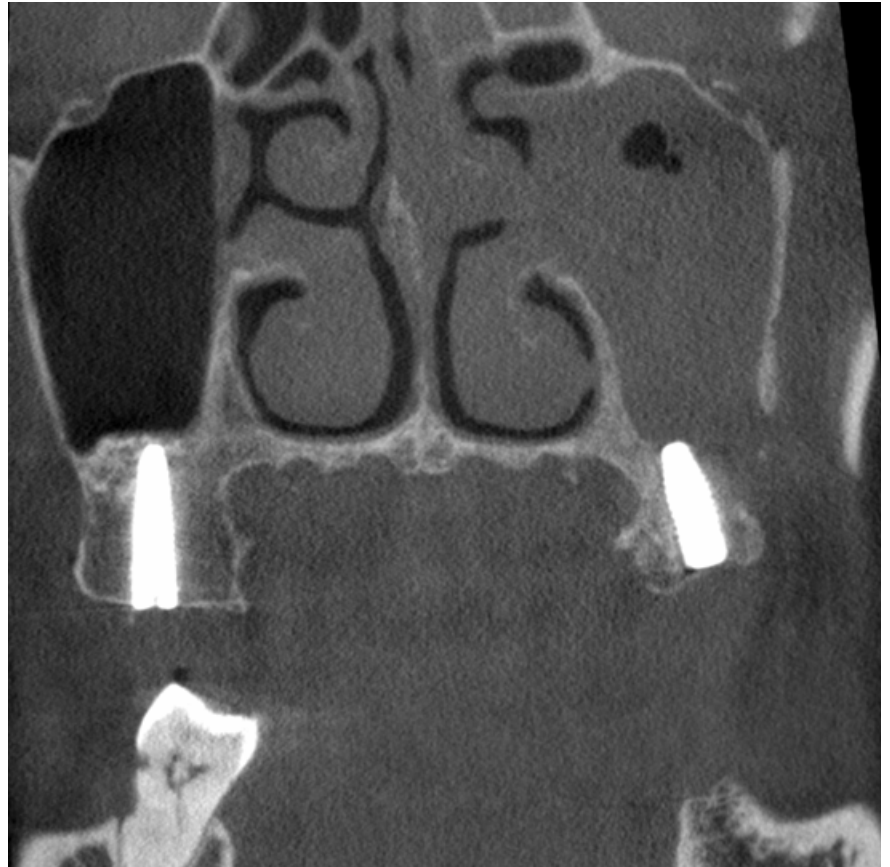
Coronal CBCT image, second molar implant regions on both sides
